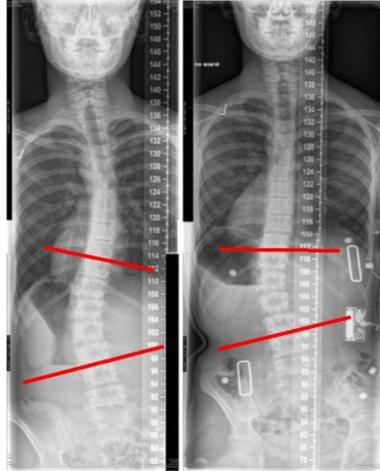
X-ray images of a patient normally (left) and wearing a brace (right). Lines defining the Cobb angle are shown.
